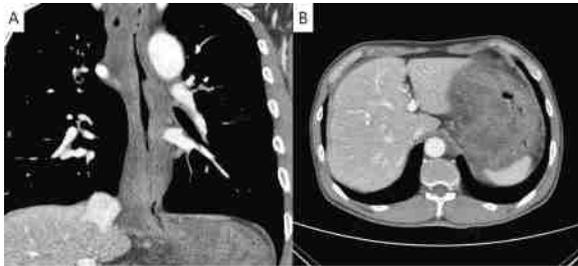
Contrast-enhanced chest computed tomography showing extensive wall thickening of the esophagus and stomach
